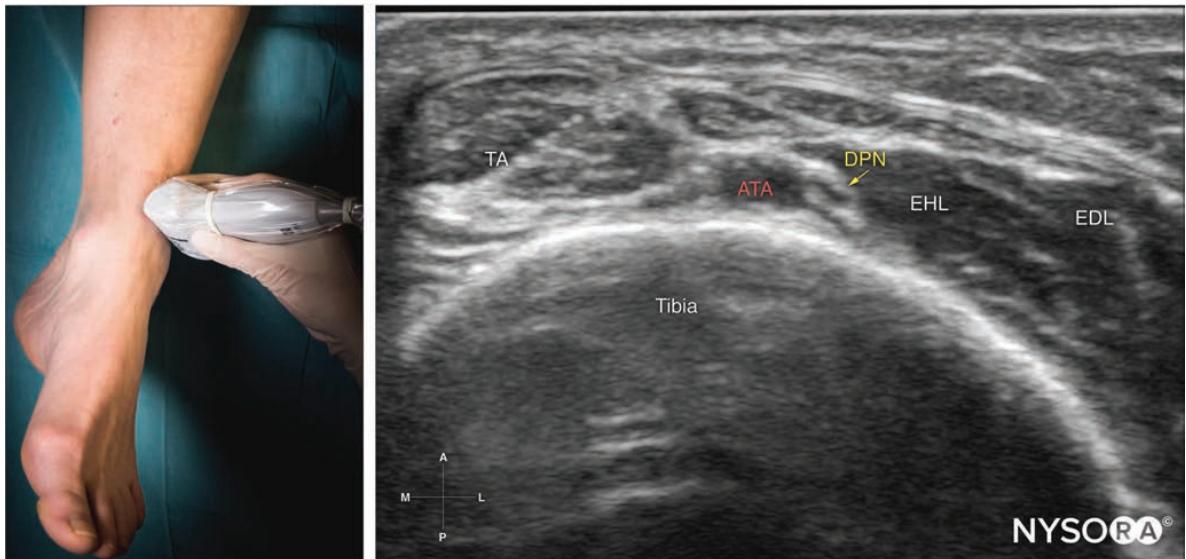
Transducer position and ultrasound anatomy to block the deep peroneal nerve. TA, tibialis anterior muscle; ATA, anterior tibial artery; DPN, deep peroneal nerve; EHL, extensor hallucis longus; EDL, extensor digitorum longus.
